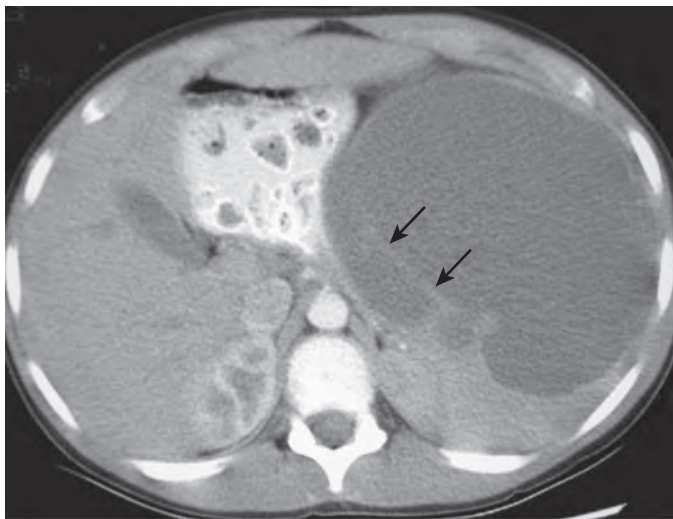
Epidermoid cyst. Contrast-enhanced CT demonstrates a large, intrasplenic cystic mass with a relatively thin wall. Notice the septa or trabeculae (arrows).
